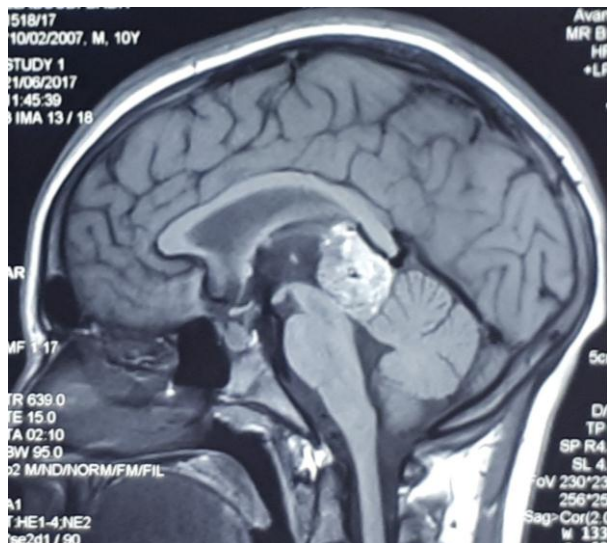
Initial MRI (sagittal plan) revealing a pineal region tumor with obstructive hydrocephalus.
